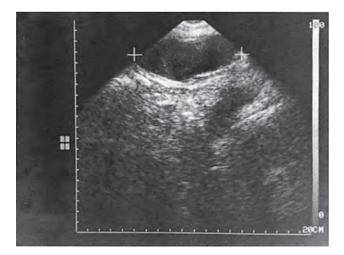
Ultrasound of the lower abdominal wall of a patient on dicoumarin therapy, who developed severe abdominal pain after a coughing spasm. The area next to the '+' shows a haematoma confined by rectus sheath.
